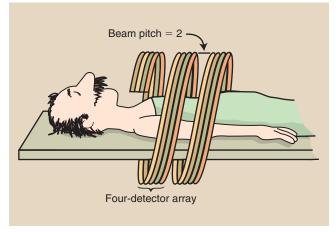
A four-slice helical computed tomography (CT) scan with a pitch of 2.0 covers eight times the tissue volume of single-slice helical CT.
